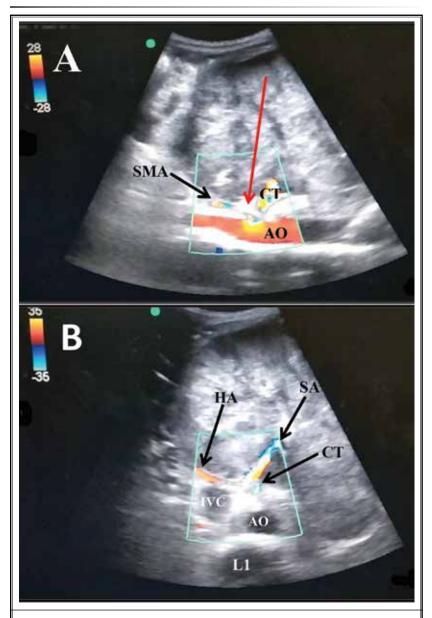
A: Longitudinal ultrasound view of the aorta (AO), the celiac trunk (CT), and the superior mesenteric artery (SMA). The red arrow represents the Needle path between the two branches, B: Cross-sectional ultrasound view of the aorta (AO), celiac trunk (CT), hepatic artery (HA), splenic artery (SA), inferior vena cava (IVC), and first lumbar vertebral body (L1).
